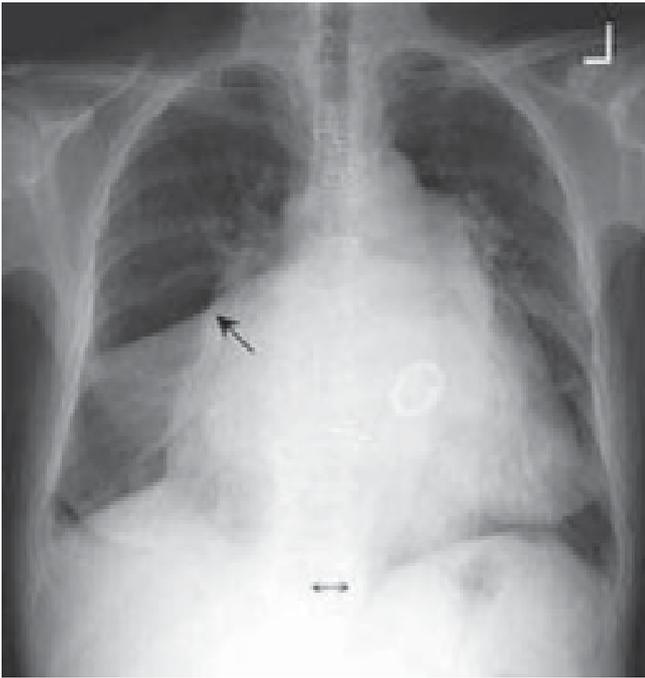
Chest radiograph of case 2 showing cardiomegaly (cardiothoracic ratio of 0.7), right middle lobe collapse as evidenced by depression of the horizontal fissure (arrow) and effacement of the right heart border. Left paravertebral tubular lucency due to laterally displaced oesophagus.
